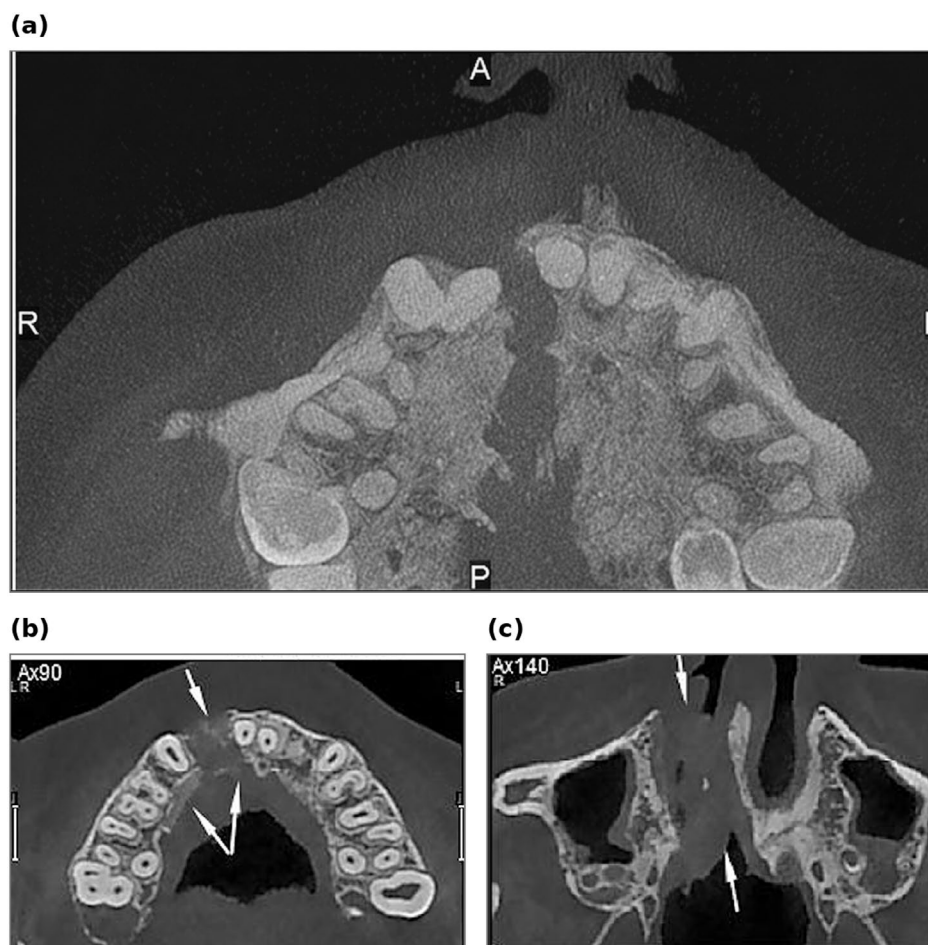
Cone-beam computed tomographic assessment of the alveolar cleft-region. (a) Preoperative axial section, before late secondary alveolar bone grafting at 17 years of age, demonstrating the residual alveolar cleft defect on the right side. (b) Axial section 1 year after grafting, showing thin bony bridging of the cleft (arrows) without bone volume sufficient to support an implant at the site of the missing right lateral incisor. (c) Corresponding coronal section 1 year after grafting, demonstrating the persistent residual alveolar bone deficiency that precluded predictable implant placement (arrows). The preoperative and postoperative examinations were acquired at different centers with different units and imaging parameters and are therefore presented as qualitative documentation of the residual defect; they were not used for quantitative comparison.
